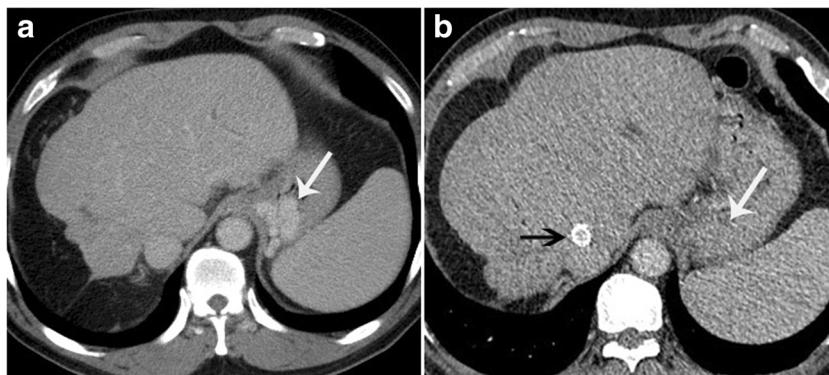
Images from a 61-year-old man with IGV-1. Pre-TIPS axial enhanced CT image (a) demonstrates submucosal components of GV (white arrow) in gastric fundus. The patient underwent TIPS creation and coil embolisation on the LGV and PGV, with PSG reduction from
